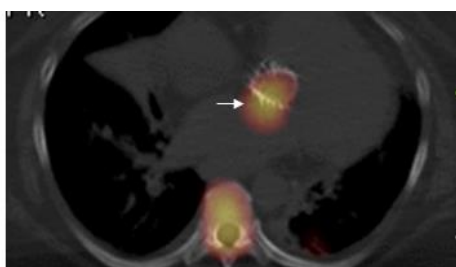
Infected prosthetic aortic valve with aortic root abscess. Axial SPECT/CT demonstrates intense uptake of indium-111 labeled leukocytes around the valve extending into the aortic root (arrow). Transesophageal echocardiogram performed 5 days earlier was negative.
